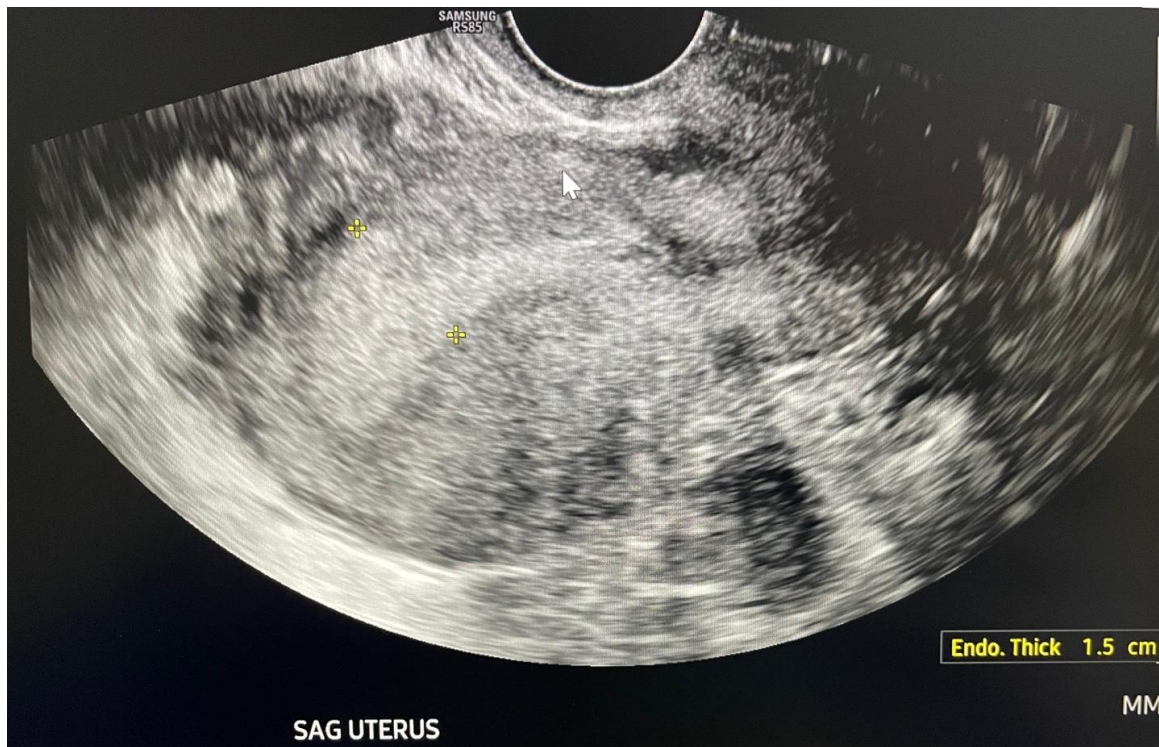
Transvaginal ultrasound image showing mildly complex free fluid in the pelvis without a discrete abscess formation
